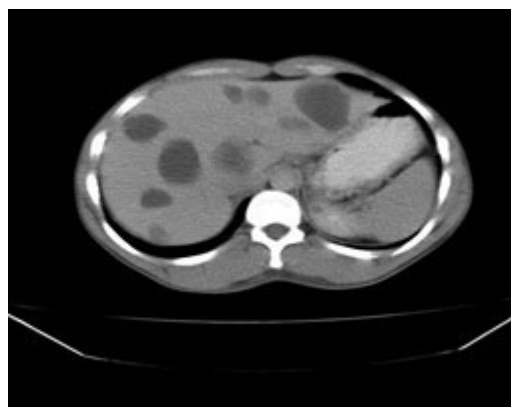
Computed tomography scan of the abdomen showing multiple hypodense nodules in both lobes of the liver.
